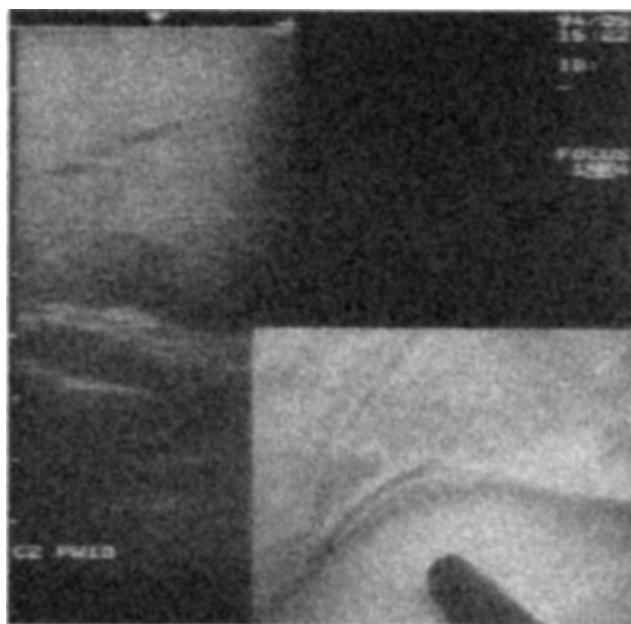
Example of how a screen divider allows viewing of laparoscopic and ultrasound images on a single monitor. The laparoscopic image shows the position of the flexible ultrasound probe, the ultrasound image can be viewed simultaneously.
